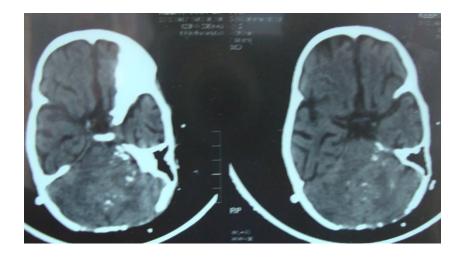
POST OP CT SCAN OF THE SAME PATIENT AFTER PARTIAL EXCISION SHOWING RESIDUAL LESION.
